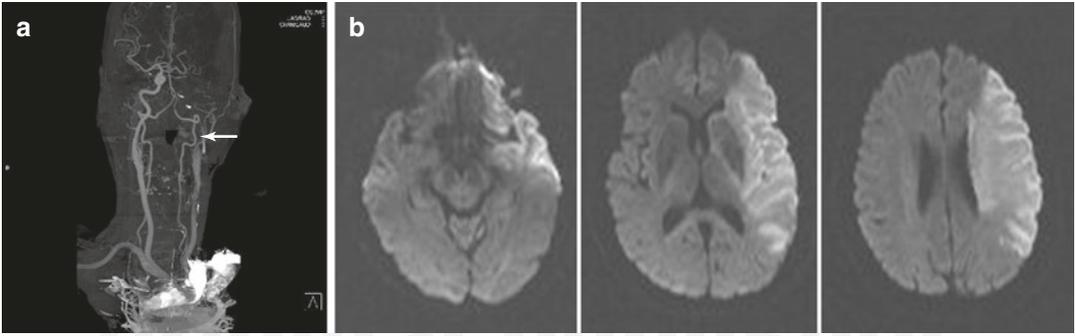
In situ thrombosis, internal carotid artery (ICA). (a) Occlusion of left proximal ICA on CT angiography. (b) Acute infarct of insular and striatocapsular region, frontotemporal cortex and subcortical white matter area on diffusion-weighted image
